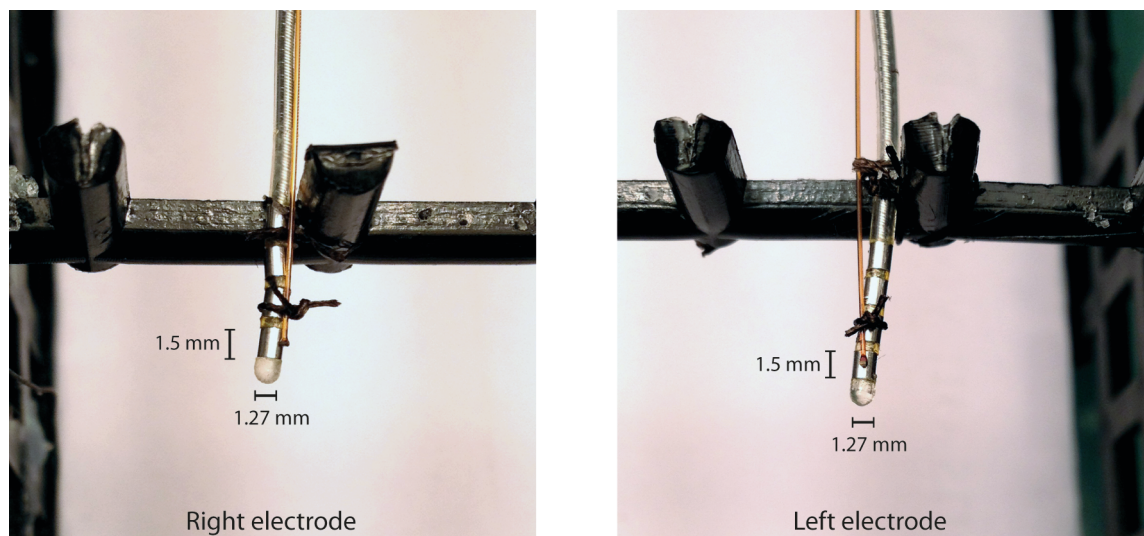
Positioning the fibre-optic probes at the distal electrode contact. The fine golden probes are the temperature probes, whereas the grey probes with 4 metal contacts on the end are the DBS electrodes. Suture silk was used to ensure that the thermometer probes were opposed to the distal electrode contacts, believed to be the site of the greatest MRI induced heating. This was fiddly.
